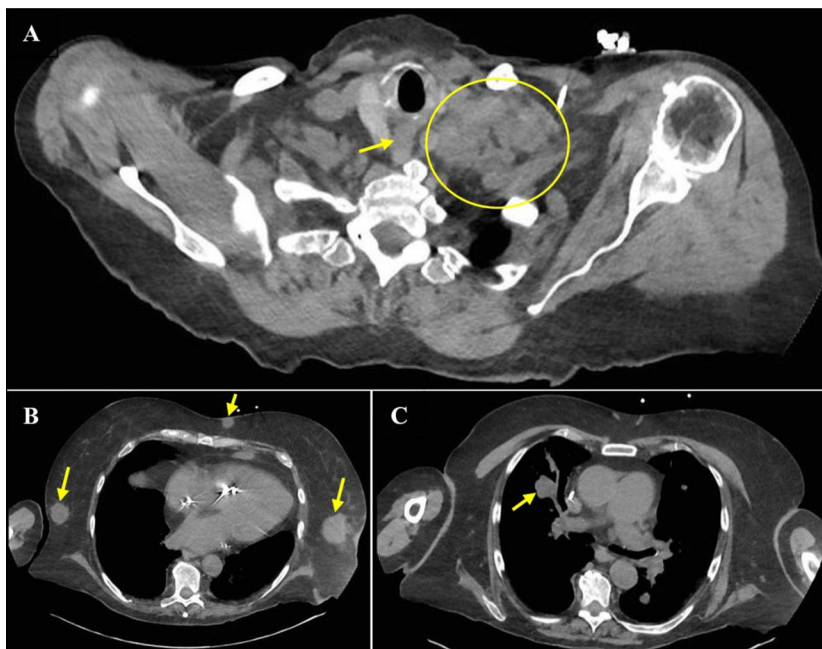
(A) Axial section of the chest CT showing mediastinal (yellow arrow) and left supraclavicular lymphadenopathy (yellow circle). (B) Axial section of the chest CT showing bilateral breast masses (yellow arrows). (C) Axial section of the chest CT showing numerous pulmonary nodules throughout the lungs, with the largest measuring 2.6 cm (yellow arrow). CT, computed tomography.
